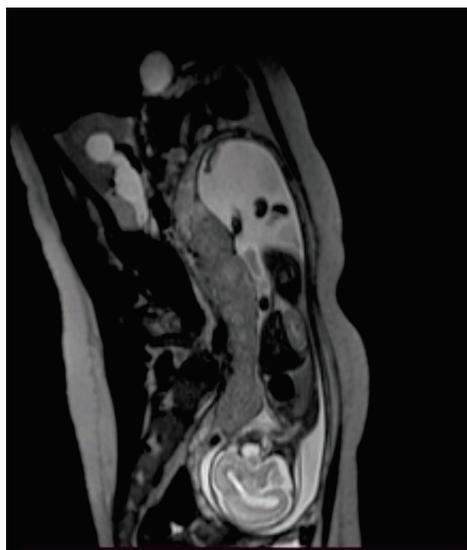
Coronal T2W MRI image that clearly shows the left liver lobe ascended in the thorax
